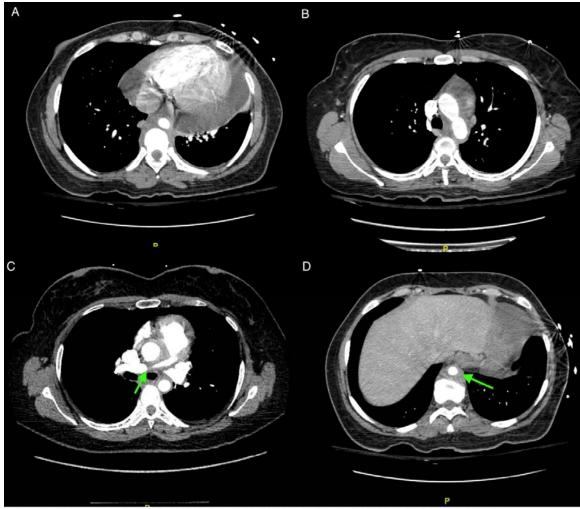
panels A-D. A chest CT scan with contrast showing (A) a soft tissue mediastinal density, (B) also surrounding the aortic arch and descending thoracic aorta extending to the prevertebral and paravertebral regions of the lower thoracic spine, with (C) mild narrowing of both pulmonary arteries within the mediastinum (green arrow on the right pulmonary artery), as well as of the (D) abdominal aorta (green arrow).
